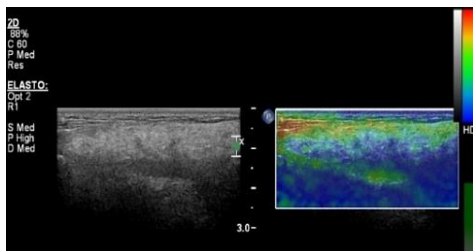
B-mode ultrasound and dynamic sonoelastography (DS) for measuring strain ratio and DS score
